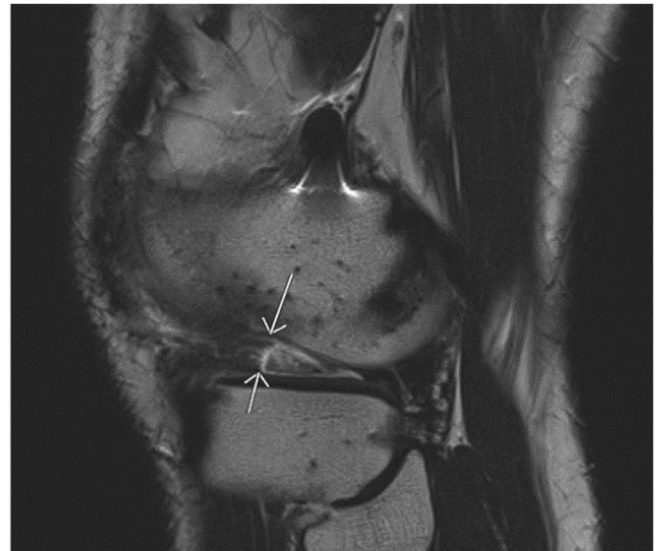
MRI evaluation. A meniscal implant rupture can be seen on the sagittal view (white arrows).
